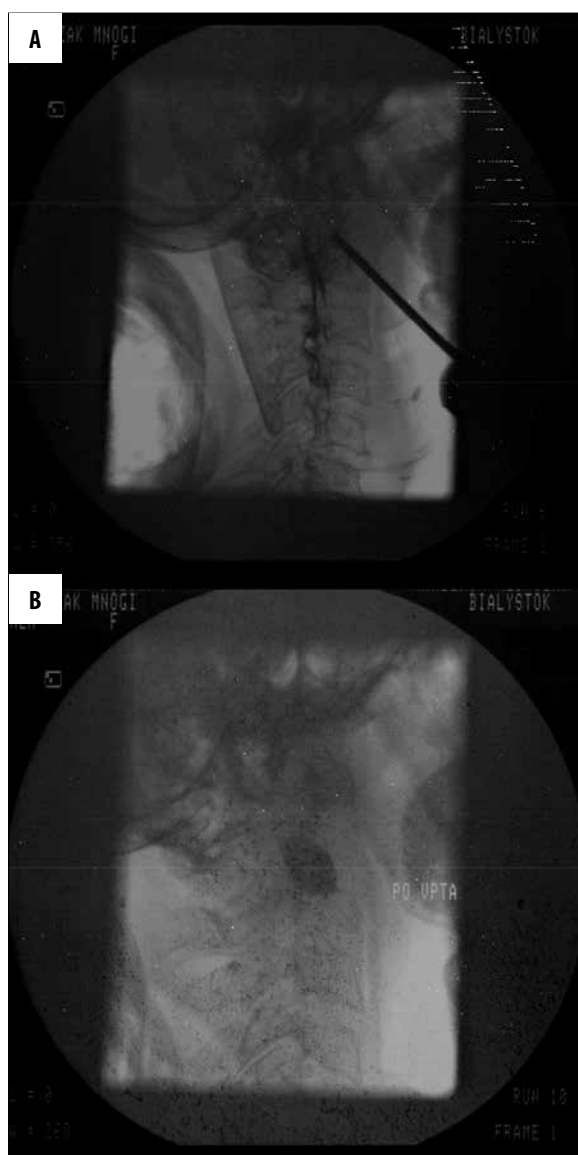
(A) C2 vertebroplasty under fluoroscopic guidance – during the procedure. (B) After the procedure. (C) After the procedure. A 71-year-old patient diagnosed with IgA multiple myeloma, with progressive symptoms during lower limb movements. Computed tomography (CT) examination showed osteolytic vertebral lesions and damage to odontoid process at a very high risk of fracture. Lower limb function recovered completely after the procedure.
